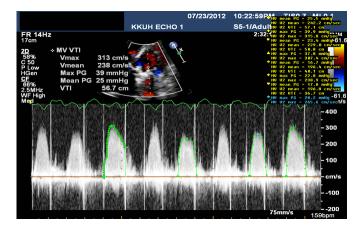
Shows the Doppler mean diastolic gradient of 23 mmHg across the metallic mitral valve.
